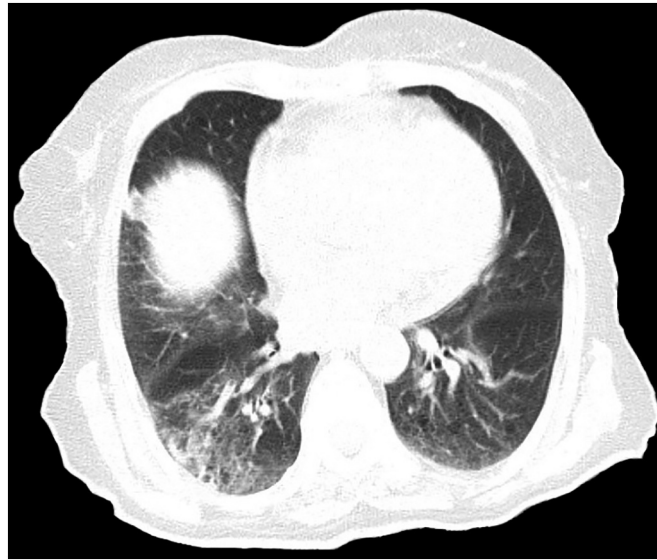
Chest computed tomography (CT) showed patchy peripheral bibasilar ground glass opacities in both lungs, findings compatible with mild Coronavirus Disease 2019 (Covid-19) pneumonia.
